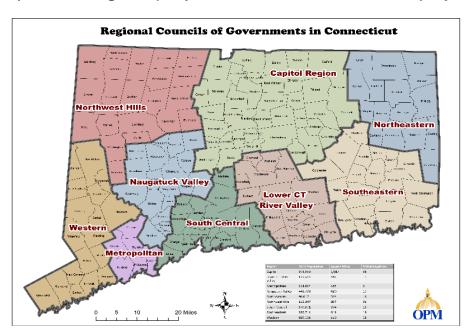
Map of CT regions
